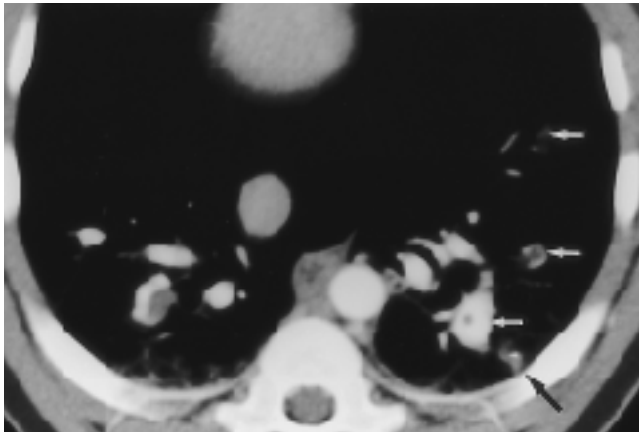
False-positive embolus due to collapsed lung parenchyma. Contrast-enhanced spiral CT scan shows filling defects in second to fifth order branches (arrows). Note low-attenuation lesion in left lower lobe (long arrow), which was false positive for pulmonary embolus. The low-attenuation lesion was due to focal consolidation of the lung.
